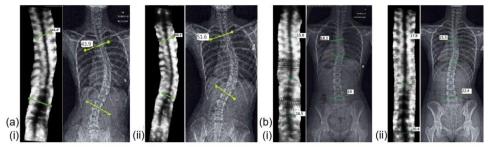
Ultrasound coronal image and radiographs with (a) a typical progressive case at (i) first visit and (ii) follow-up visit; and (b) a typical non-progressive case at (i) first visit and (ii) follow-up visit
